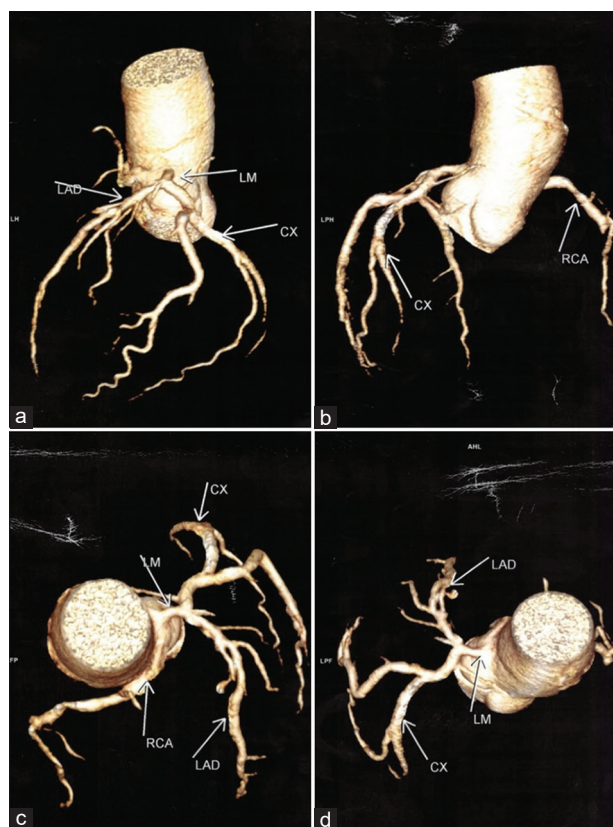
Multidetector computed tomography three-dimensional reconstruction volume rendered images of coronary anatomical course: (a) Left anterior oblique view (b) posterior view (c and d) Cranial views; depicting abnormal anatomy of right coronary artery arising from left coronary cusp along with left main anatomy and its course further dividing into left anterior descending artery and left circumflex artery. LAD: Left anterior descending, LM: Left main, CX: Circumflex artery, RCA: Right coronary artery
